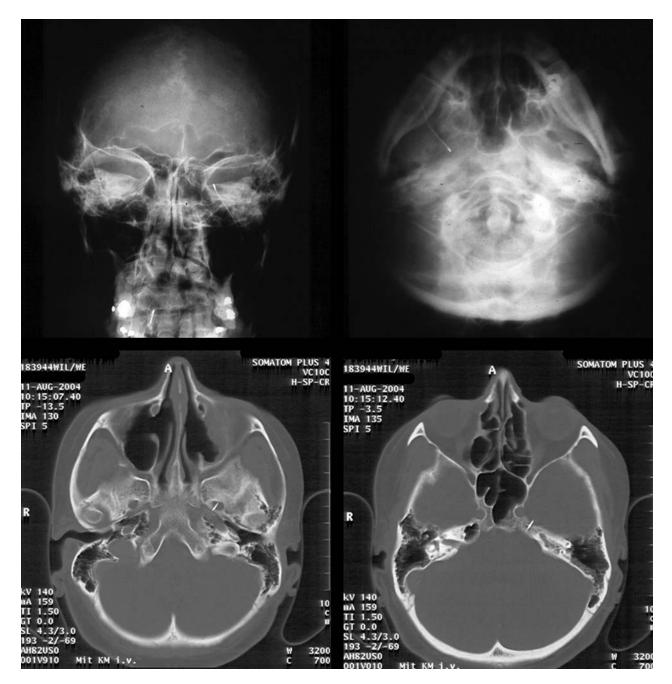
Radiographic control showing the electrode passing through the oval foramen with its tip in the Cavum Meckeli on conventional x-ray (*upper row*) and CT (*lower row*) of the skull base
